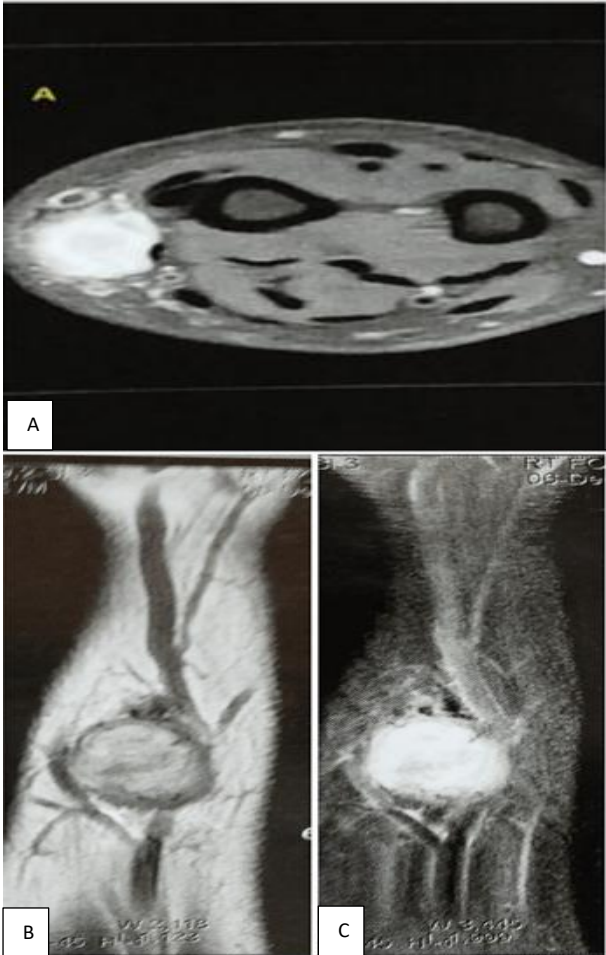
(A-C): Axial and coronal section of MRI demonstrating subcutaneous lesion.
